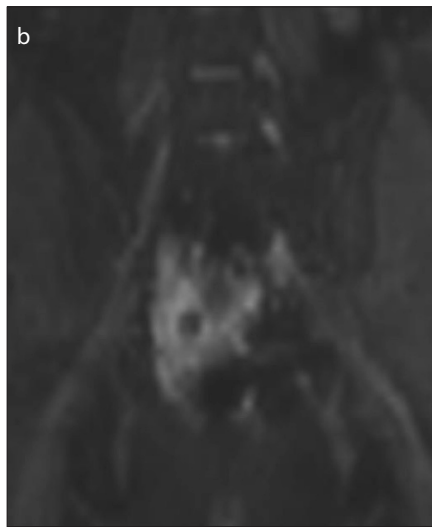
a–e. A 57-year-old female presenting with buttock pain and back pain and diagnosed with left piriformis syndrome. She received an injection with Botox and had a positive response. Coronal 3D inversion recovery turbo spin-echo (IR TSE) image (a) shows asymmetrically hyperintense left sciatic nerve (*thick arrow*) at the sciatic notch compared to normal right sciatic nerve (*thin arrow*). Coronal maximum intensity projection (MIP) DTI image ($b=600 \text{ s/mm}^2$) (b) shows hyperintense left sciatic nerve. Axial T1-weighted image (c) shows left piriformis hypertrophy. CT-guided injection (d) with Botox and contrast of the left piriformis muscle. CT-guided injection (e) into the sciatic nerve (*black arrow*) showing the needle tip (*thin white arrow*), and the contrast (*thick white arrow*).
